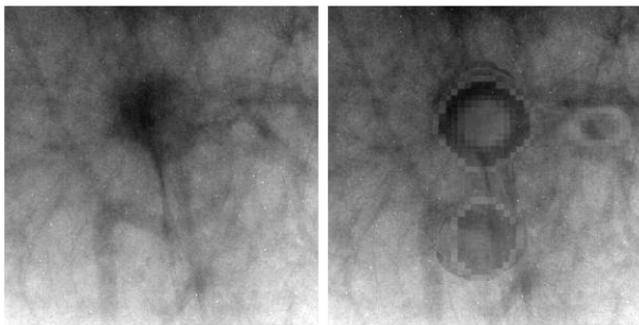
6 mm X-ray suspected breast cancer (left) and overlap with scintigraphic image (right)
